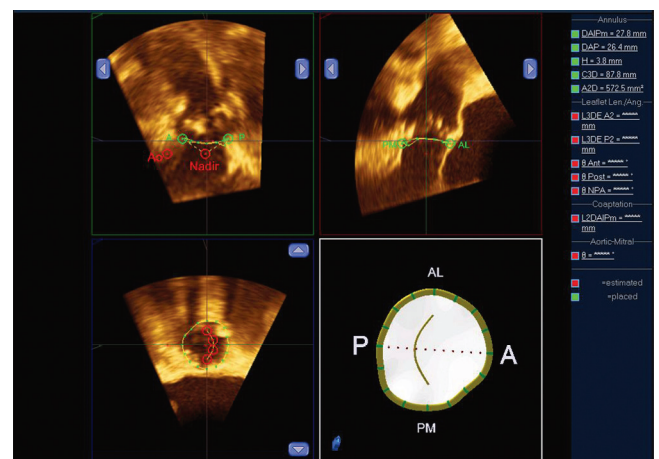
■ Transesophageal echocardiogram with three-dimensional reconstruction measuring the aortic annulus area.
